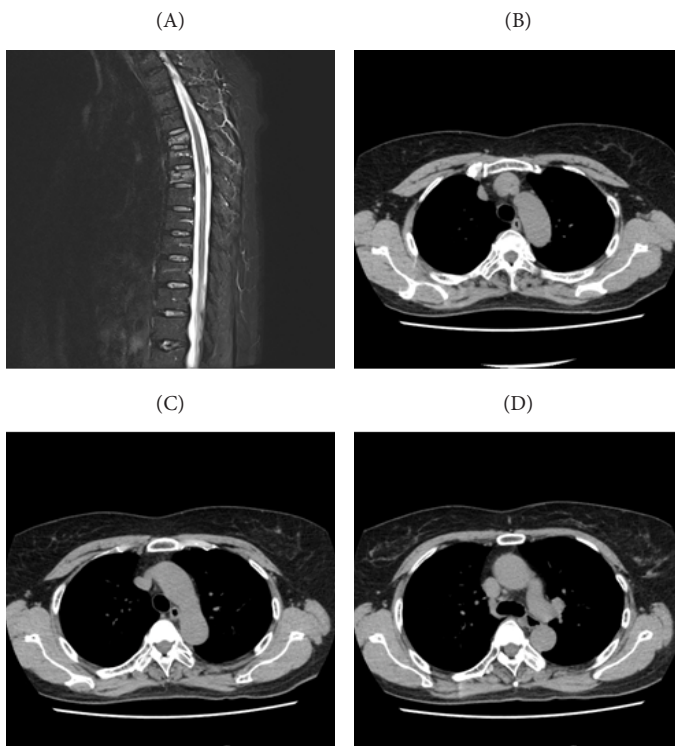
T-spine MRI & CT on 2020.03.03. (A) T-spine MR STIR, (B) T4 CT, (C) T5 CT, (D) T6 CT. CT, computerized tomography; MRI, magnetic resonance imaging.
